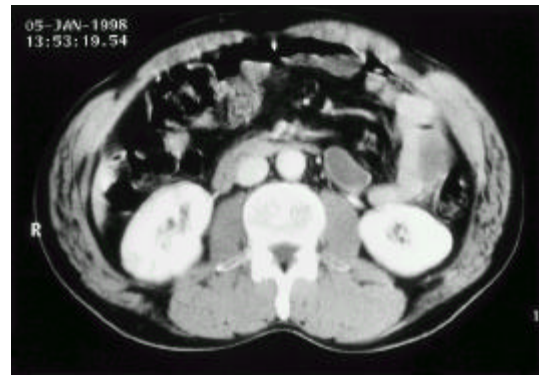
Follow-up abdomen CT scan shows no residual mass of the IVC.
